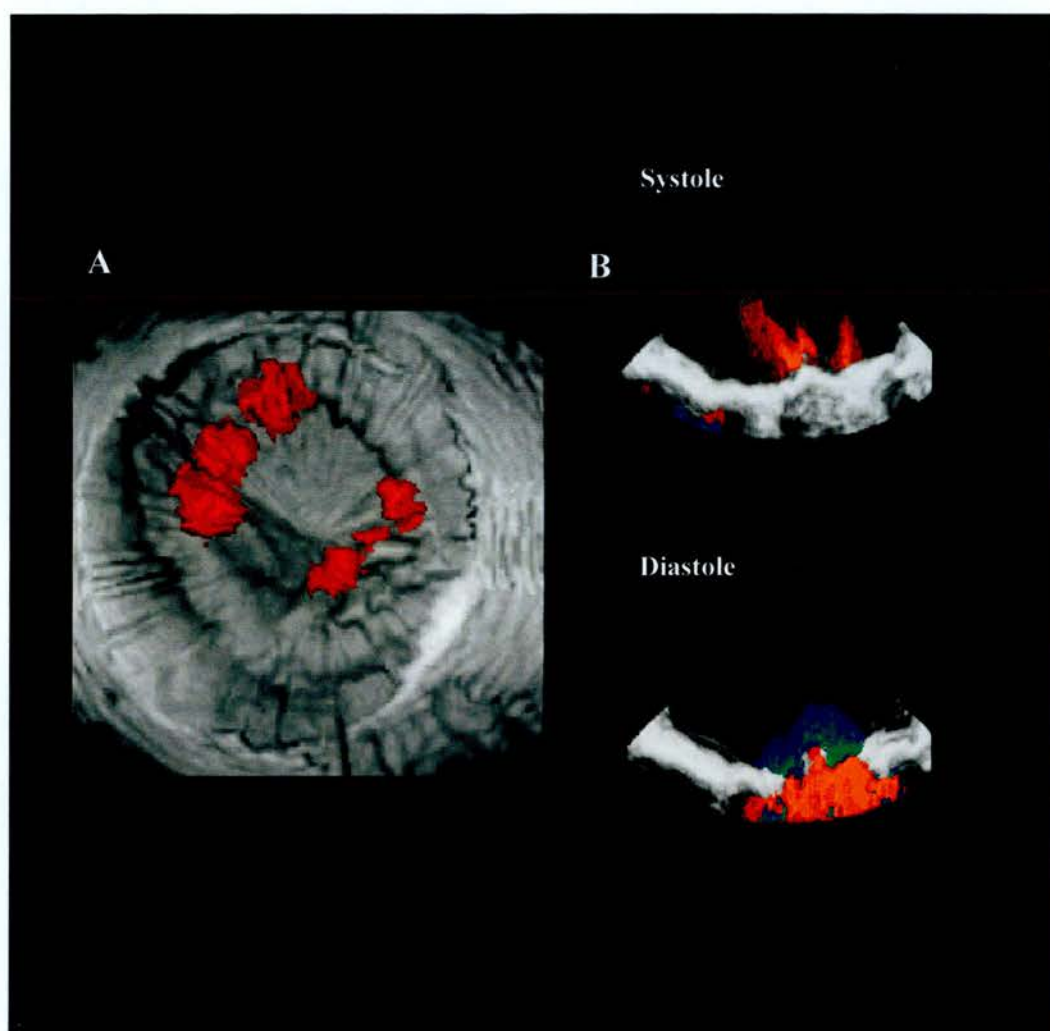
Example of transthoracic three-dimensional (3D) reconstruction of a regurgitant prosthetic mitral valve. (A), *en face* (short-axis) view of the prosthetic mitral valve reconstruction from an atrial perspective with corresponding (B) long-axis views during systole (top) and diastole (bottom). 3D reconstructions contain both grey-scale data and colour Doppler jets displaying a complex mechanism of valve insufficiency. (courtesy of Dr Andreas Franke & Dr Harald Kühl, University Hospital Aachen, Germany).
